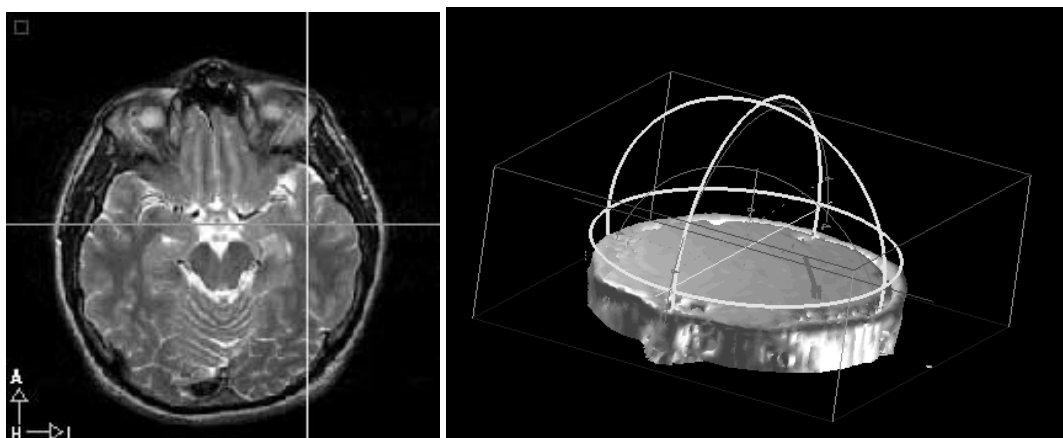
Dipole location results on a patient's MRI. The dipole appears in a Left Temporal area.
